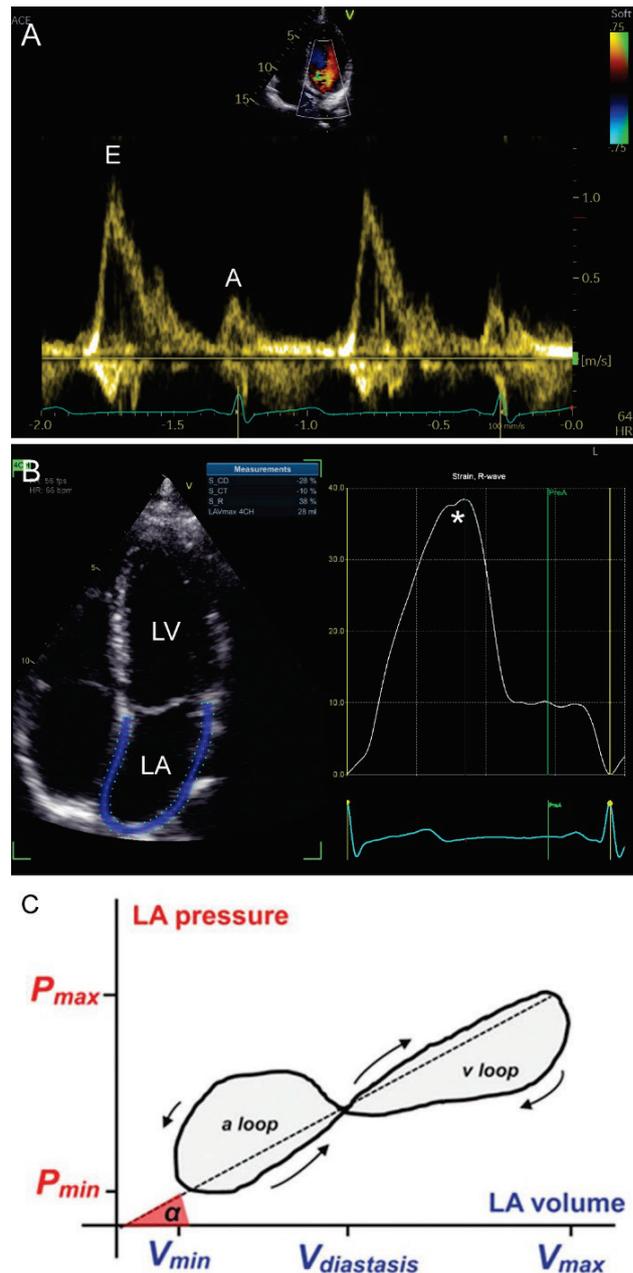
The echocardiogram showing (A) transmittal Doppler flow representing filling of the left ventricle, (B) 2D speckle-tracking imaging assessing the LA where peak of the curve (*) shows the LA reservoir function, (C) PV loop of the LA (from Melenovsky *et al.* [109]; LV = left ventricle, LA = left atrium, E = the passive filling of the ventricle during diastole, A = the late active filling phase representing atrial contraction, P = pressure, V = volume, a loop = atrium loop, v loop = ventricle loop, α = LA stiffness is represented by slope of dashed line that connects maximal and minimal pressure-volume points.
